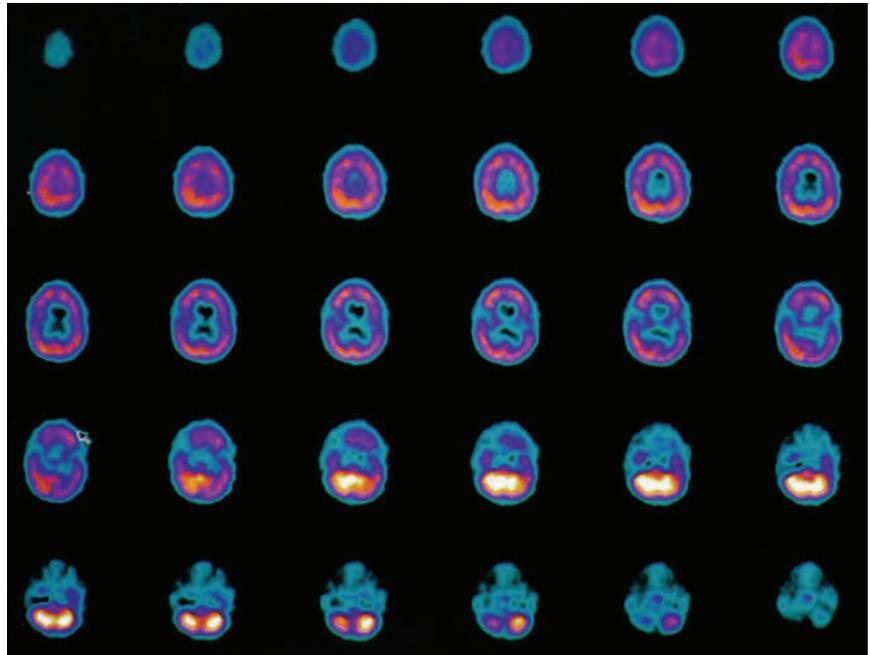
HMPAO SPECT brain imaging transverse slices 4 months and 80 HBO treatments after Fig. 20.10. Note persistent improvement to blood flow to the frontal lobes over baseline scan of Fig. 20.10a
